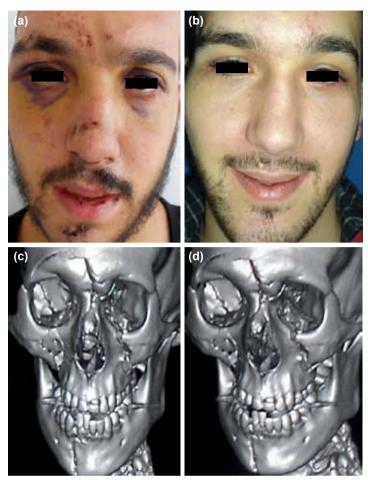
The photograph of the patient injured in a traffic accident with bilateral combined orbital fracture. (a) Pre-operative view of the patient. (b) Three months after bilateral orbital fracture reconstruction surgery via subciliary incision. (c, d) Pre-operative three-dimensional computed tomography scans.
